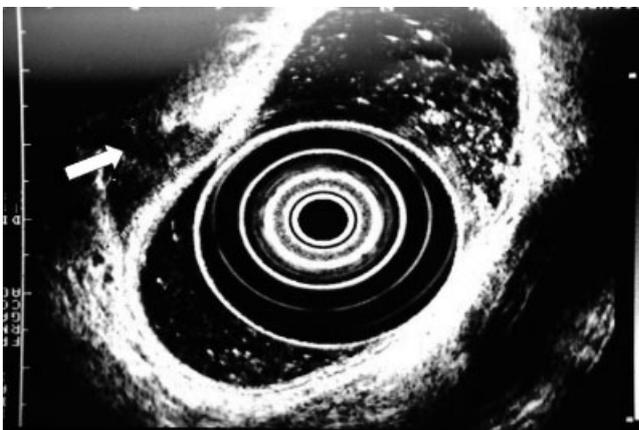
Rectal endoscopic ultrasound image showing involvement of the rectal wall by deeply infiltrating endometriosis (arrow).
